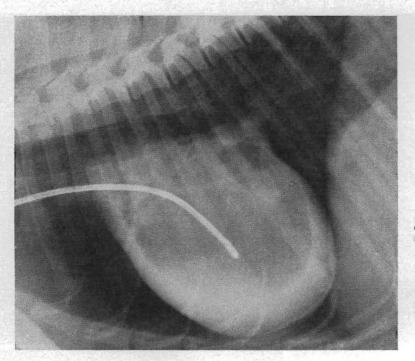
Radiograph made after 7 cc. of a contrast material had been injected into the pericardial sac. The amount of blood in the pericardial sac at this time was not known, and clinical evidence of cardiac tamponade was not vet detectable.
